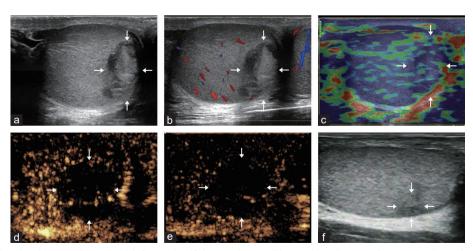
A 31-year-old male with scrotal trauma. (a) Grayscale US image shows a 21-mm, irregular, non-circumscribed margin, and hypoechoic lesion (arrowheads) in the right testis. (b) Color Doppler US image shows absence of vascularization. (c) Strain elastography image shows a medium-to-hard (encoded blue–green) focal lesion. (d) Early and (e) late phases CEUS show the lesion with nonenhancement. (f) The lesion decreases in size significantly one month later. Three months later, the lesion disappears completely. Finally, it is confirmed to be a testicular hematoma. The arrows indicate testicular hematoma. US: ultrasound; CEUS: contrast-enhanced US.
